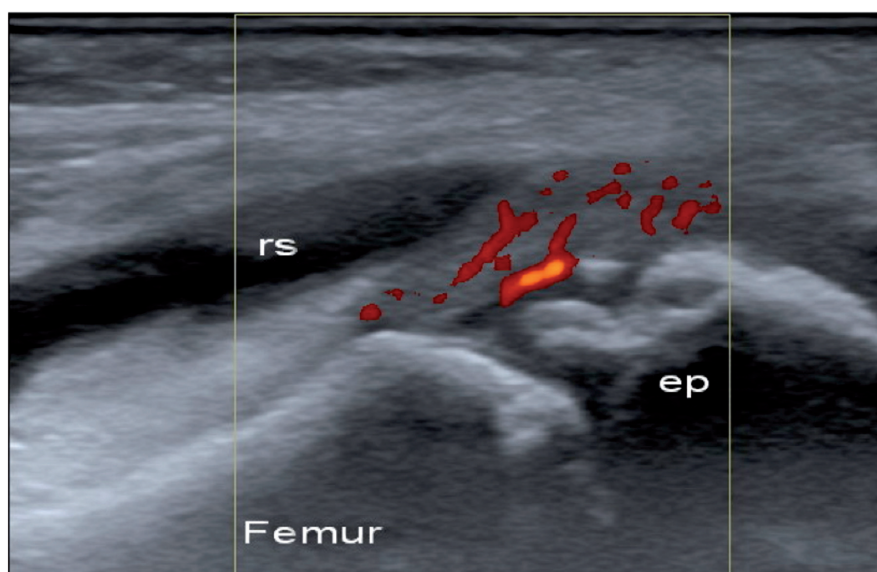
Juvenile idiopathic arthritis. Anterior longitudinal US scan of the knee in a 7-year-old child. Bone erosion in ossific centre of epiphysis (ep) of the femur surrounded by hypertrophied synovial tissue with hyperaemia. Power Doppler examination also shows vascularisation at the level of the erosive lesion and cartilage surface. Note the presence of pathological effusion in the suprapatellar recess (rs).
